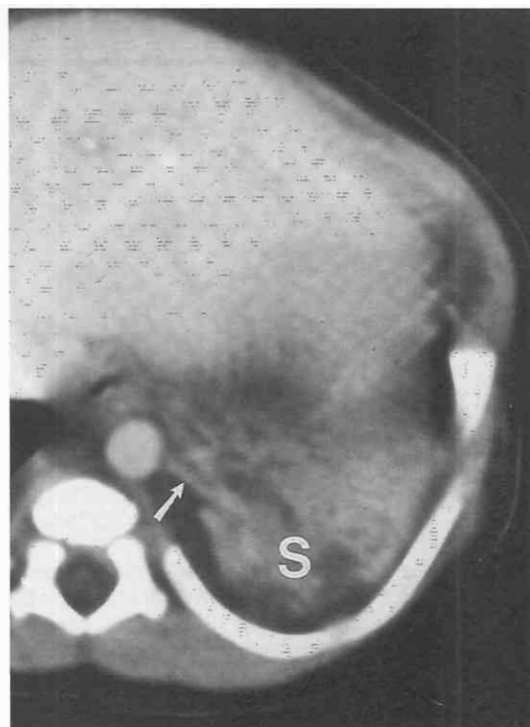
Sequestration in a 1-day-old boy. CT scan shows abnormal opacity (S) within the left lower lobe. An enhancing systemic artery (arrow) is seen arising from the aorta and leading into the lung opacity.
